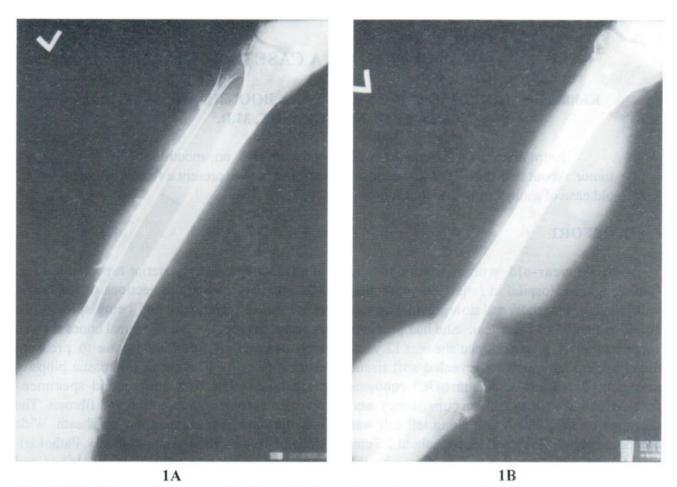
A,B Plain radiographs of left leg (AP, lateral) showing large soft tissue masses at dorsal foot and calf with cortical spiculation of tibula and tarsal bone
